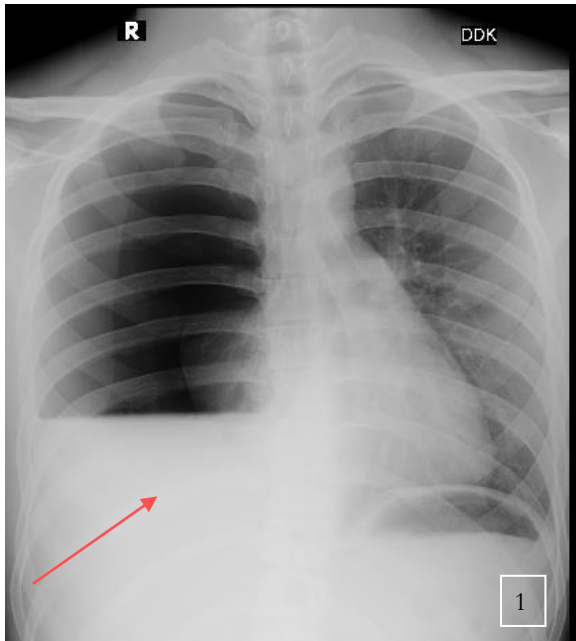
The first-day photograph of the chest x-ray. The red arrow shows an avascular hyperradiolucent section with a fluid water level indicating hydropneumothorax. Conclusion: right hydropneumothorax
